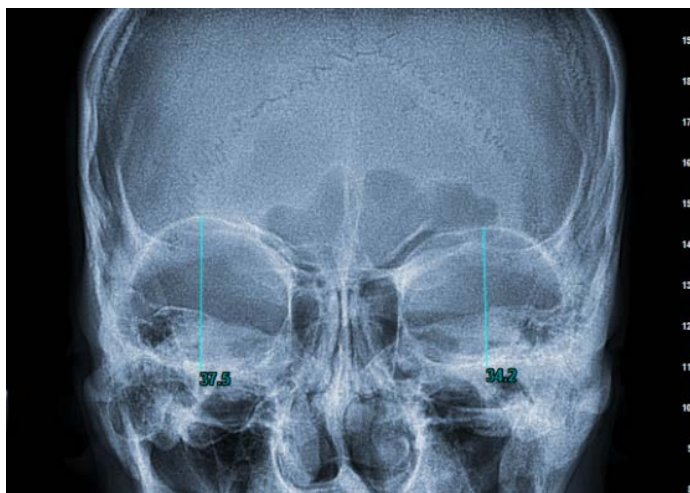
orbital height measurements of a male patient on postero-anterior radiographs using Newtom digital software
